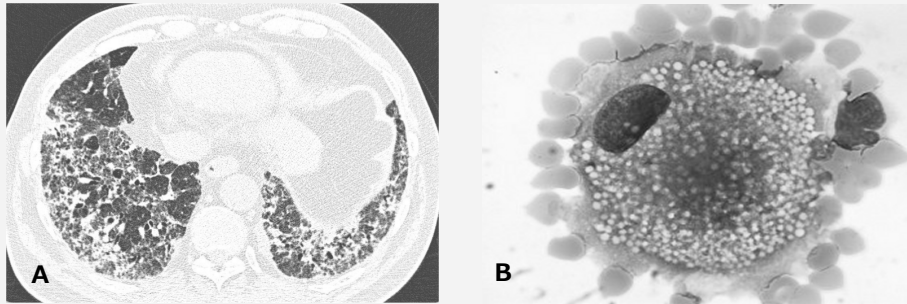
(A) High resolution CT-scan; (B) Foamy alveolar macrophage.
